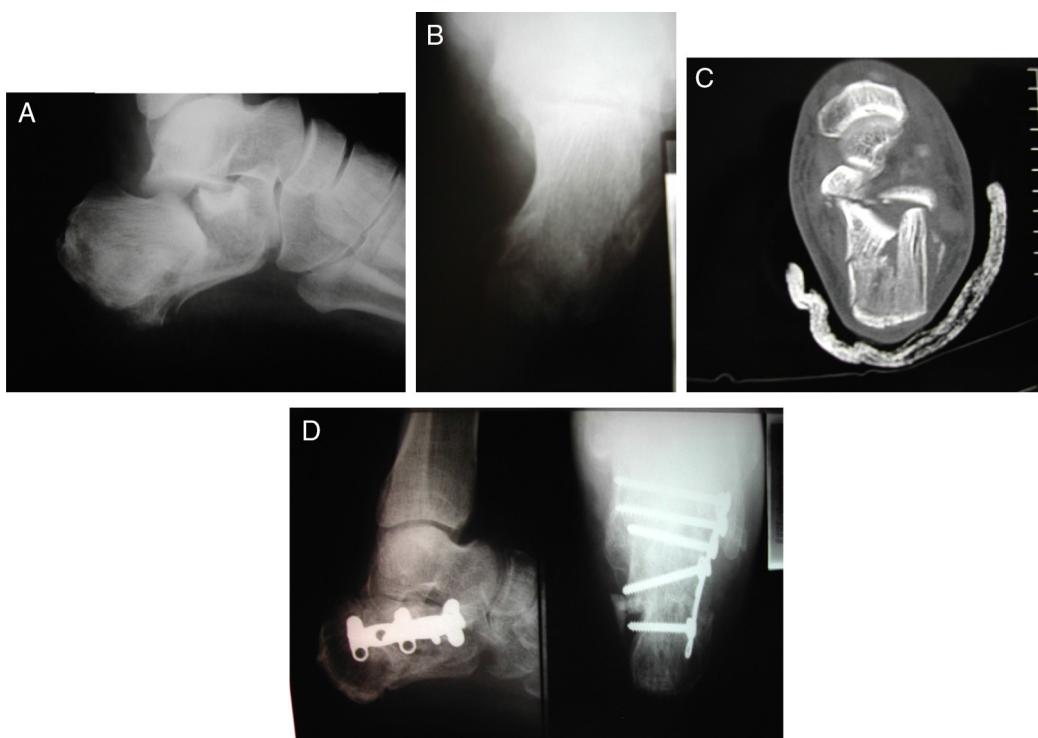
Example of displaced intra-articular calcaneal fracture, classified as Sanders II and treated with open reduction and internal fixation. (A) Anteroposterior X-ray of the calcaneus; (B) axial X-ray of the calcaneus; (C) coronal plane CT-scan; (D) post-operative result.
